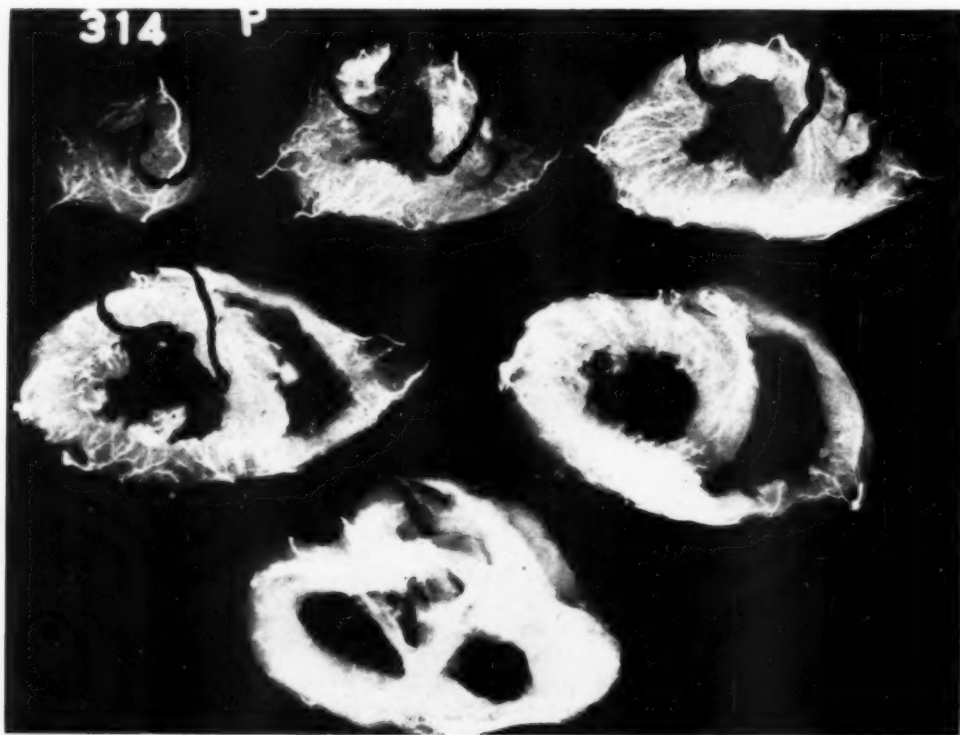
Roentgenogram of the heart of Case 8, showing rupture of the anterior wall in the second segment
